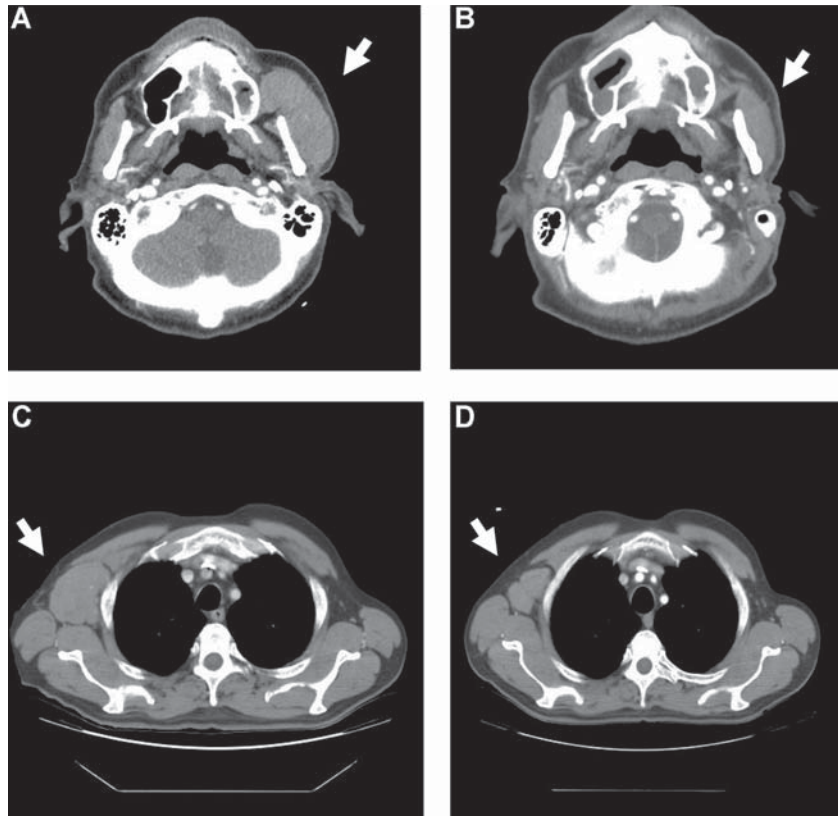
Regression of malignancy in a patient with mantle cell lymphoma. CT scans from patient 0414 (dose level 1.0 mg/kg) showing left parotid (A,B), and right axillary (C,D) nodal masses before (A,C) and 1 month after (B,D) ipilimumab infusion.
